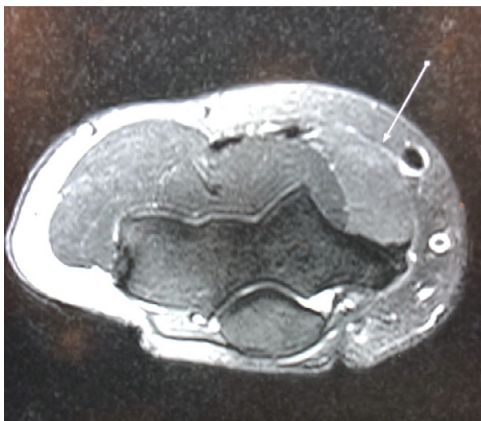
Postexercise axial with IV contrast fat-saturated T2 MRI sequence of the patient's forearm, demonstrating generalized muscle edema in the pronator teres.
